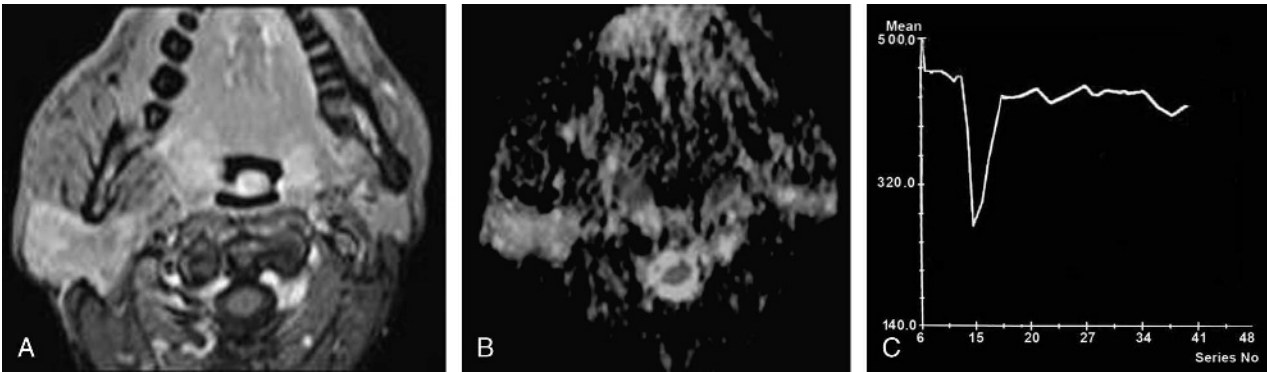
Mucoepidermoid carcinoma. A, Axial contrast T1-weighted image shows heterogeneously enhancing soft tissue mass involving the deep lobe of the right parotid gland. B, Axial ADC map shows restricted diffusion of the lesion with ADC value of $0.98 \times 10^{-3} \text{ mm}^2/\text{s}$. C, Time signal intensity curve shows the DSC% of the lesion is 46.1%.
